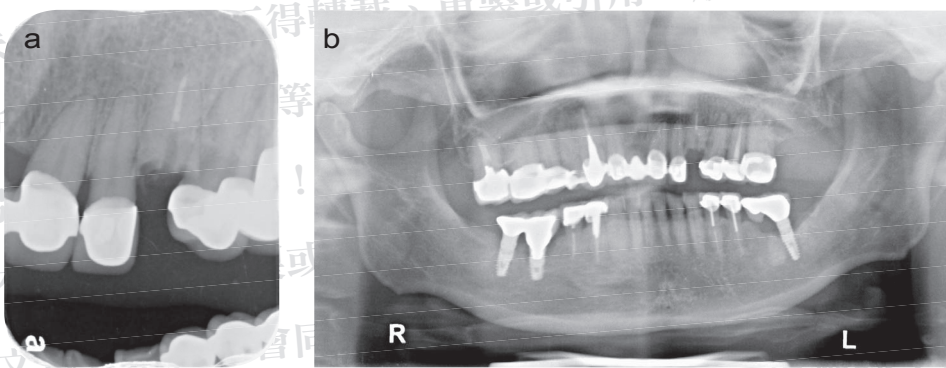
Periapical and panoramic radiographs of tooth #23, an unrestorable fractured tooth, which was extracted in the following treatment sequence.
